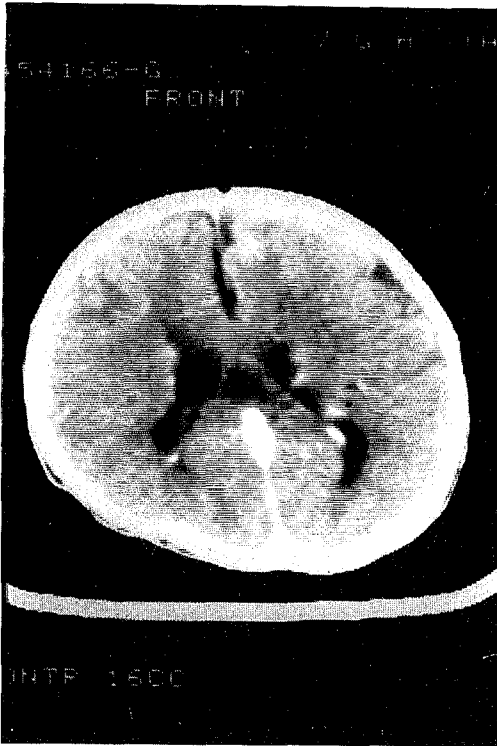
CT scan of brain at the age of 7 months showing multiple periventricular nodular calcifications.
